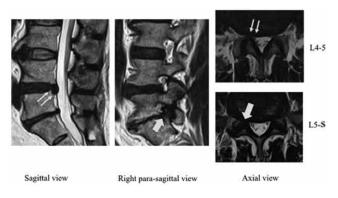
Magnetic resonance images (MRI) before surgery. The panel on the left shows a sagittal view, small arrows indicate the herniated nucleus pulposus at L4-5, and it is compressing the right L5 nerve root. The panel in the center shows a right para-sagittal view; big arrow indicates right foraminal stenosis at the level of L5-S. On the axial view, lateral recess stenosis at L4-5 (small arrows) and foraminal stenosis at L5-S (big arrow) is noted.
